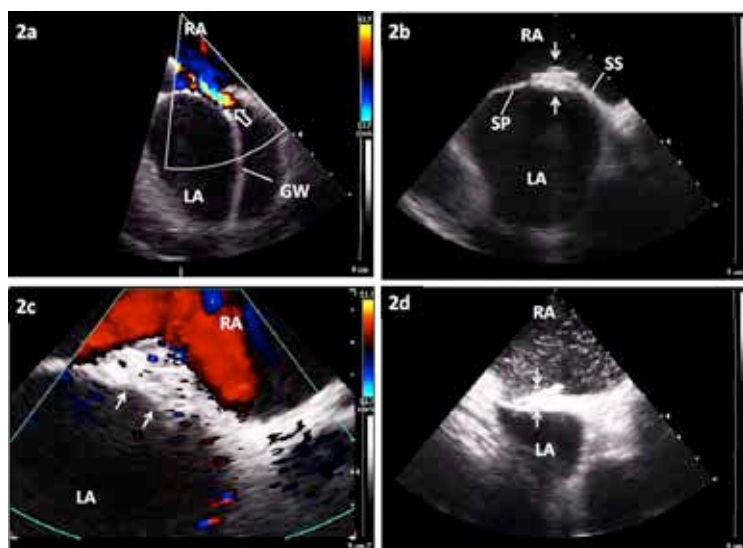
A 40-year-old active man who had no conventional cardiovascular risk factor presented with transient neurological signs and symptoms (lasting approximately 7 hours) consistent with, in the opinion of the treating neurologist, transient ischemic attack. There was no MRI evidence of ischemic lesion. He had extensive investigation and a patent foramen ovale with right-to-left shunt on Valsalva manoeuvre was identified. Despite aspirin therapy, he experienced a recurrent event 5 months later. This episode lasted for 12 hours without MRI evidence of ischemic lesion. It was felt that device closure should be offered to the patient, and after detailed discussion, he opted to undergo the procedure. Under ICE and fluoroscopic guidance, the PFO measured a) 6 mm in diameter and 10 mm in length on balloon sizing (white open arrow). This was successfully closed with a 20-mm GSO® (white arrows) and b) the ICE images showed low device profile with good conformity to the interatrial septum. No residual shunt was identified on c) colour flow mapping and d) agitation saline contrast on the release of Valsalva. GW, guide wire; LA, left atrium; RA, right atrium; SP, septum primum; SS, septum secundum.
